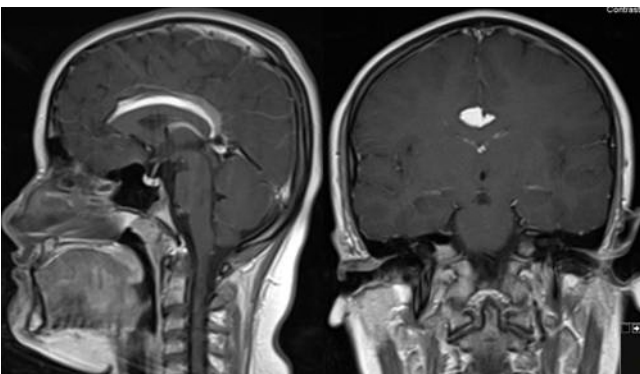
Contrast enhancement does not appear on the T1-weighted sagittal and coronal sections
